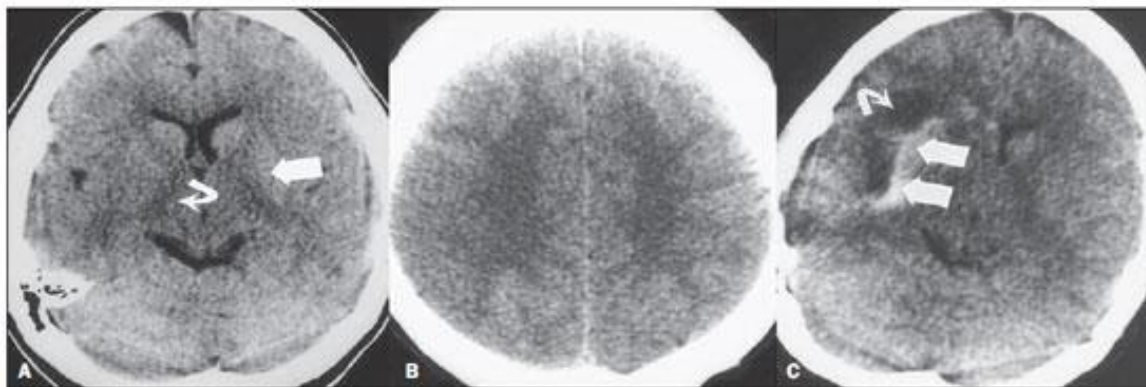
A. CT scan six hours after symptoms. The curved arrow denotes medial demarcation of the posterior portion of the right internal capsule. Note that the lateral margin of the right internal capsule is poorly defined, due to the decreased attenuation of the lentiform nucleus. The straight arrow shows the normal left internal capsule and lentiform nucleus. B: Decreased white-gray differentiation in the right cerebral hemisphere, corresponding to the distribution of the MCA. C: Three days later - area of greater attenuation (straight arrows) corresponding to hemorrhage in a region of infarction. The non-hemorrhagic areas of infarction are seen as hypoattenuating (curved arrow) Source: (21).
